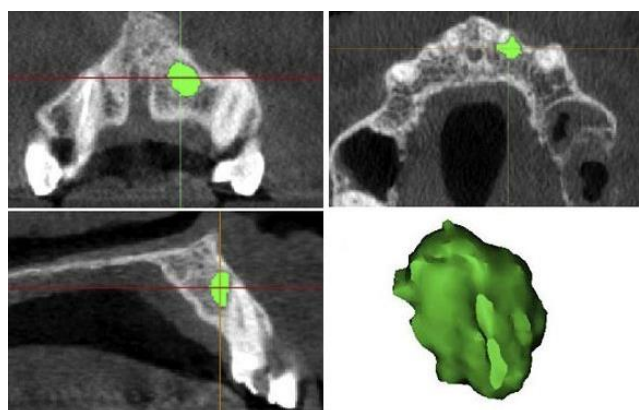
Axial, coronal, sagittal slices and stereolithography format for assessing the volume of periapical lesion (9).
